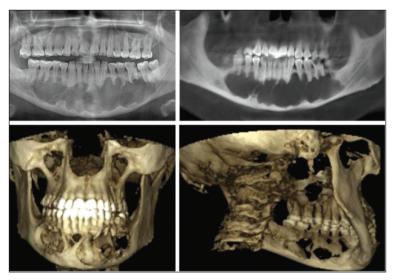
Initial panoramic radiography and computed tomography scans of the patient.
